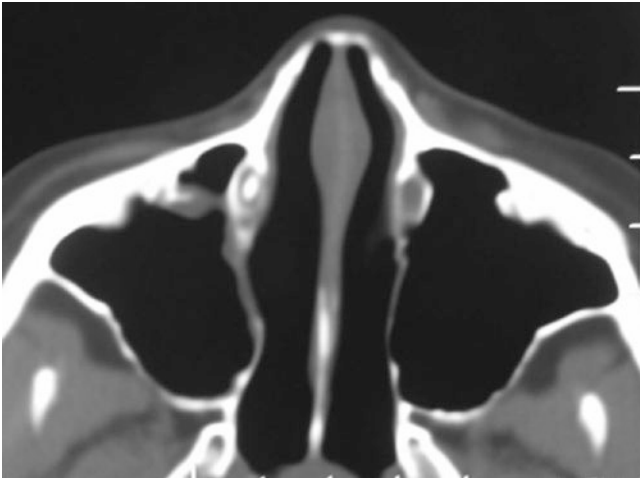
CT-DCG, axial image, showing presence of dye in the right nasolacrimal duct, while it is absent on the left side, indicating obstruction
